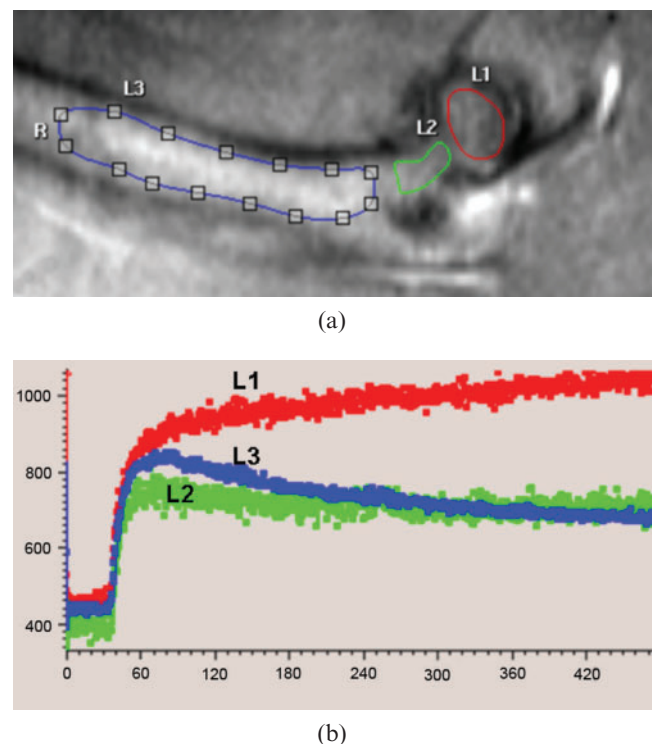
(a) T_1 weighted anatomical image depicting femoral head (L1), femoral neck (L2) and proximal femoral diaphysis (L3). (b) Dynamic contrast-enhanced MRI time-signal intensity curve (y-axis: signal intensity in arbitrary units; x-axis: time in seconds). In the proximal femoral diaphysis, signal intensity curve drops after peak enhancement in proximal femoral shaft (L3, blue line). In contrast, after a rapid rising phase the time-signal intensity curve in the femoral head continues to increase slowly, and no washout is observed 440 s post-contrast injection (L1, red line). The time-signal intensity curve of femoral neck is close to femoral shaft although the washout curve is flatter than that of the proximal femoral diaphysis. R, right (femur).
